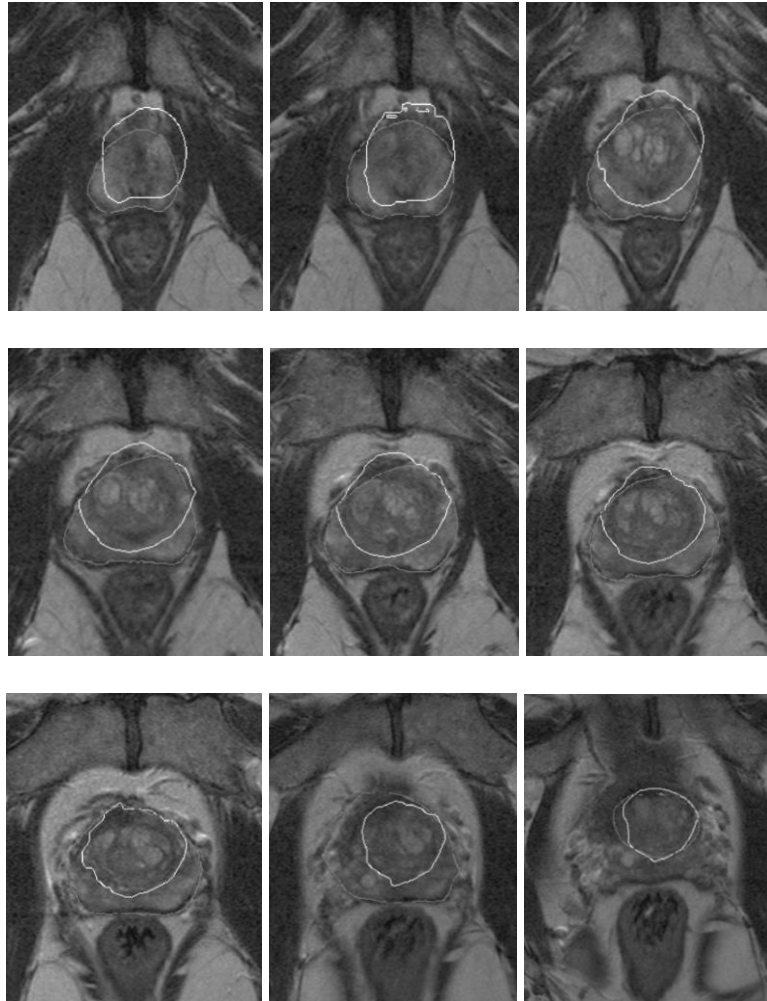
3D segmentation of an MRI image using the GA.
